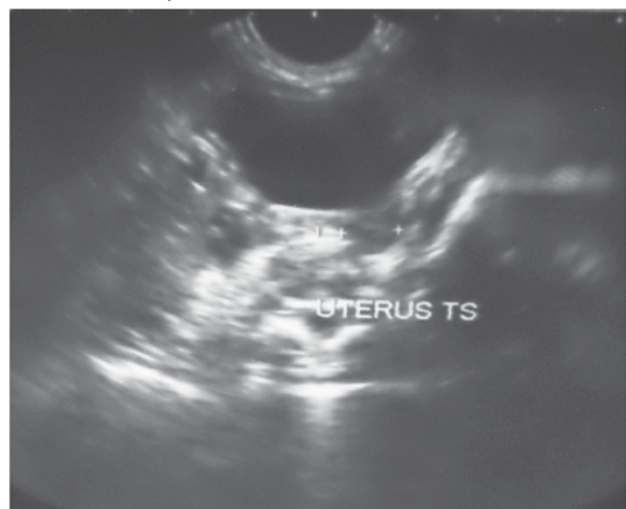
Ultrasonography of pelvis showing the presence of uterus (age 7 month)
